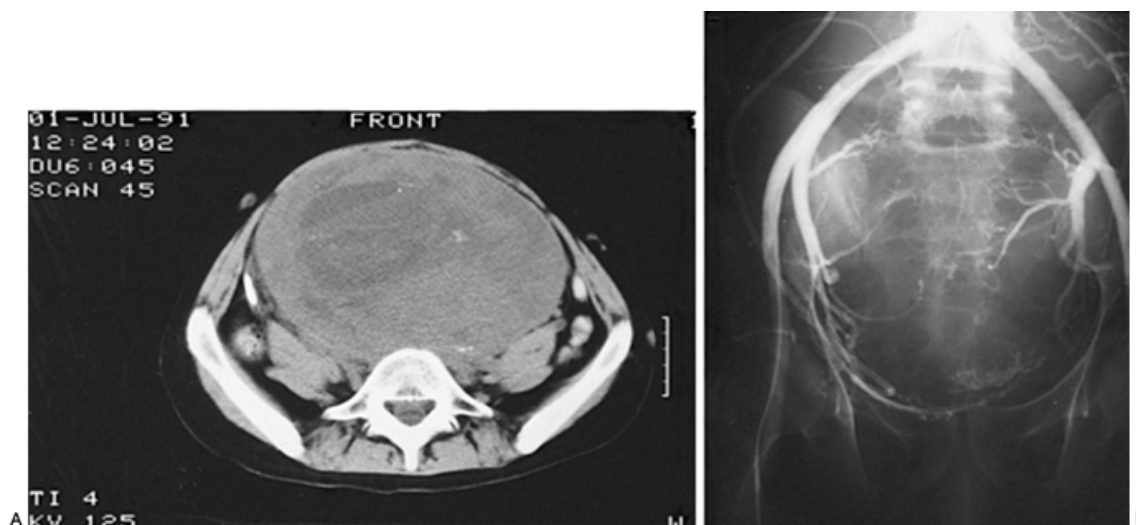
A: Computed tomography scan of the pelvis demonstrates huge recurrent malignant Schwannoma. B: Arteriogram demonstrates vascular anatomy and tumor blood supply. Resection of this tumor required performance of a hemipelvectomy.
